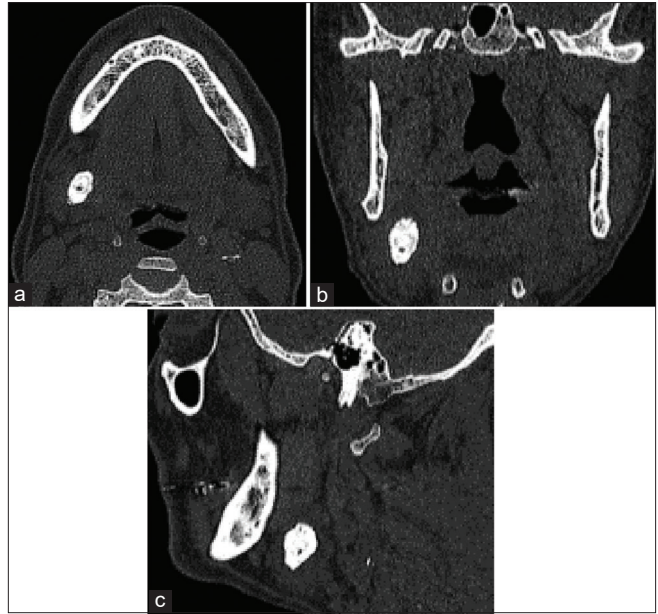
Computed tomography sections showing well-circumscribed area (hyperattenuating) close to the submandibular gland. (a) Axial, (b) coronal, (c) sagittal
